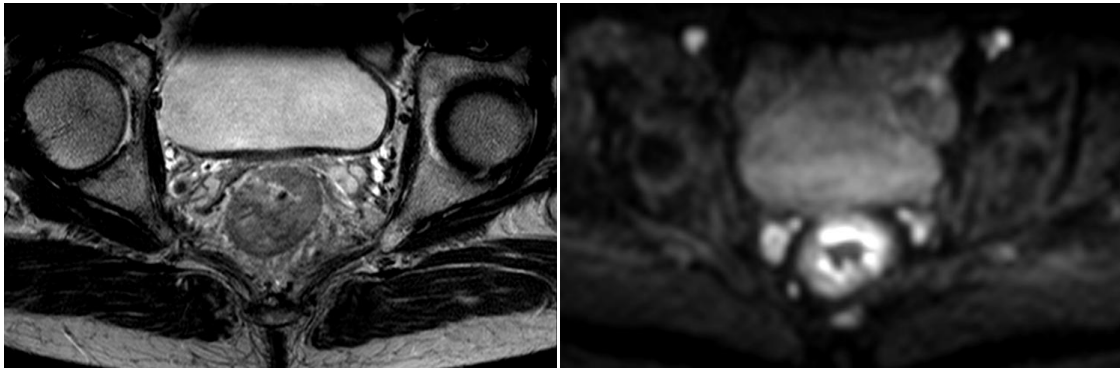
a and b: Rectal tumour prior to CRT on T2x and DWI
